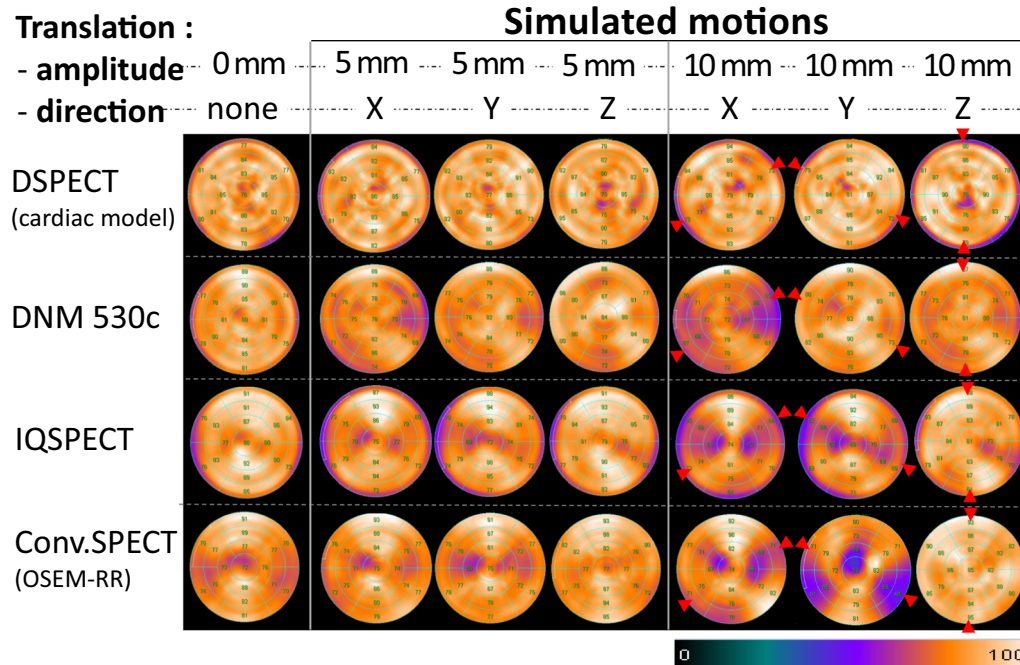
Polar maps of the SPECT images obtained with the four cameras using the recommended reconstruction parameters at baseline and for 5- or 10-mm translations in the positive X, Y, or Z directions. Red arrows, corresponding to the translation direction (see Figure 5), are additionally inserted on the polar-maps obtained with the 10-mm motions.
